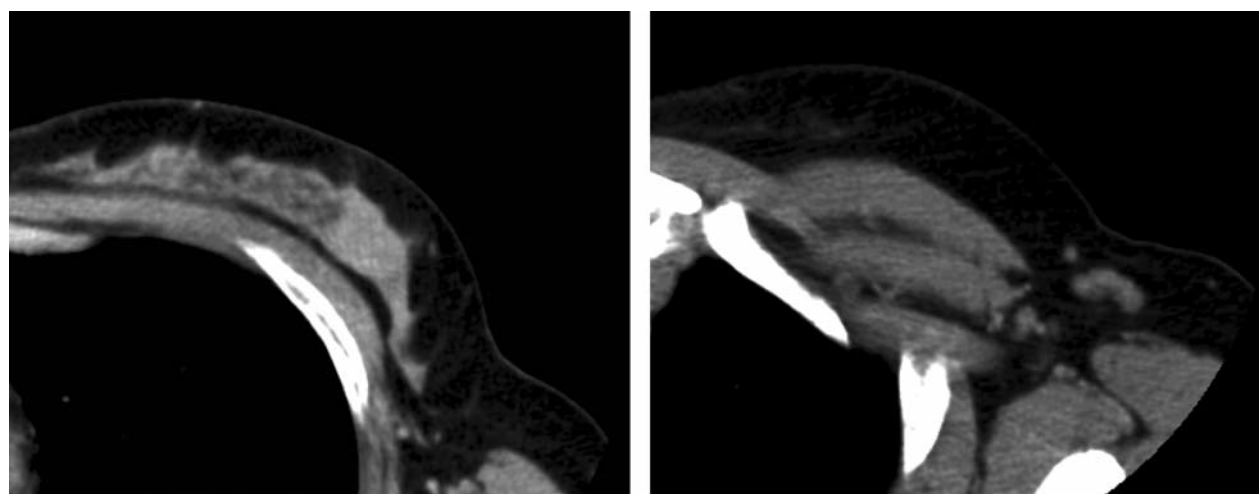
Computed tomography examination demonstrated a tumor in the left breast, which was enhanced by a contrast medium, and a large axillary lymph node was slightly enhanced.
